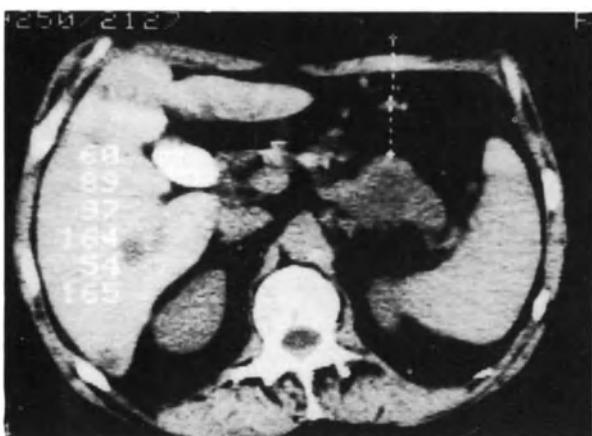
CT guided needle biopsy of small adenocarcinoma in the tail of the pancreas. Low density liver metastases. (Courtesy of Dr D. Sutton.)
